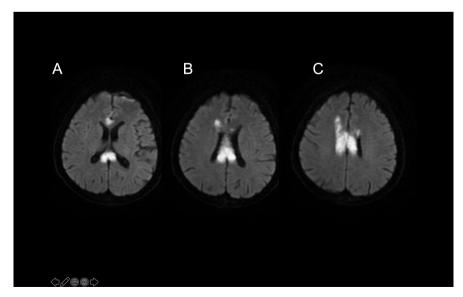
Diffusion-weighted magnetic resonance imaging revealed bilaterally restricted diffusion in the (A) genu, splenium, and (B, C) body of the corpus callosum.
